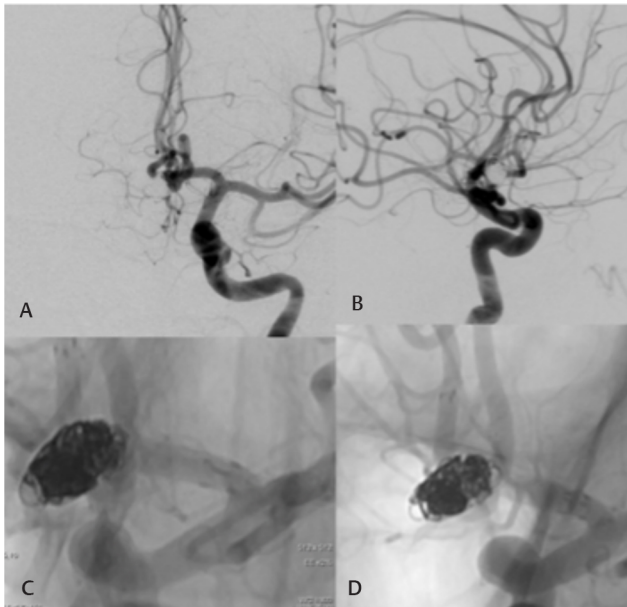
Case 4: (A–C) right middle cerebral artery (MCA) bifurcation aneurysm in digital subtraction angiography (DSA), (D) DSA image of Y stent-assisted coiling, computed tomography brain on initial presentation showing subarachnoid hemorrhage, (E–G) subdural bleed on either sides, (H) DSA of right MCA bifurcation aneurysm in follow-up.
